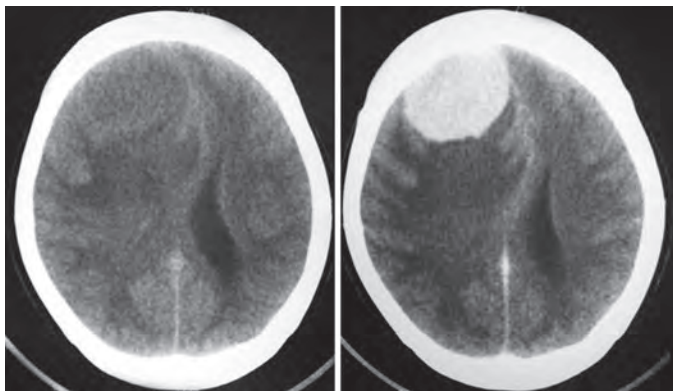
CT scan showing frontal convexity meningioma isodense on plain study and uniform contrast enhancement
